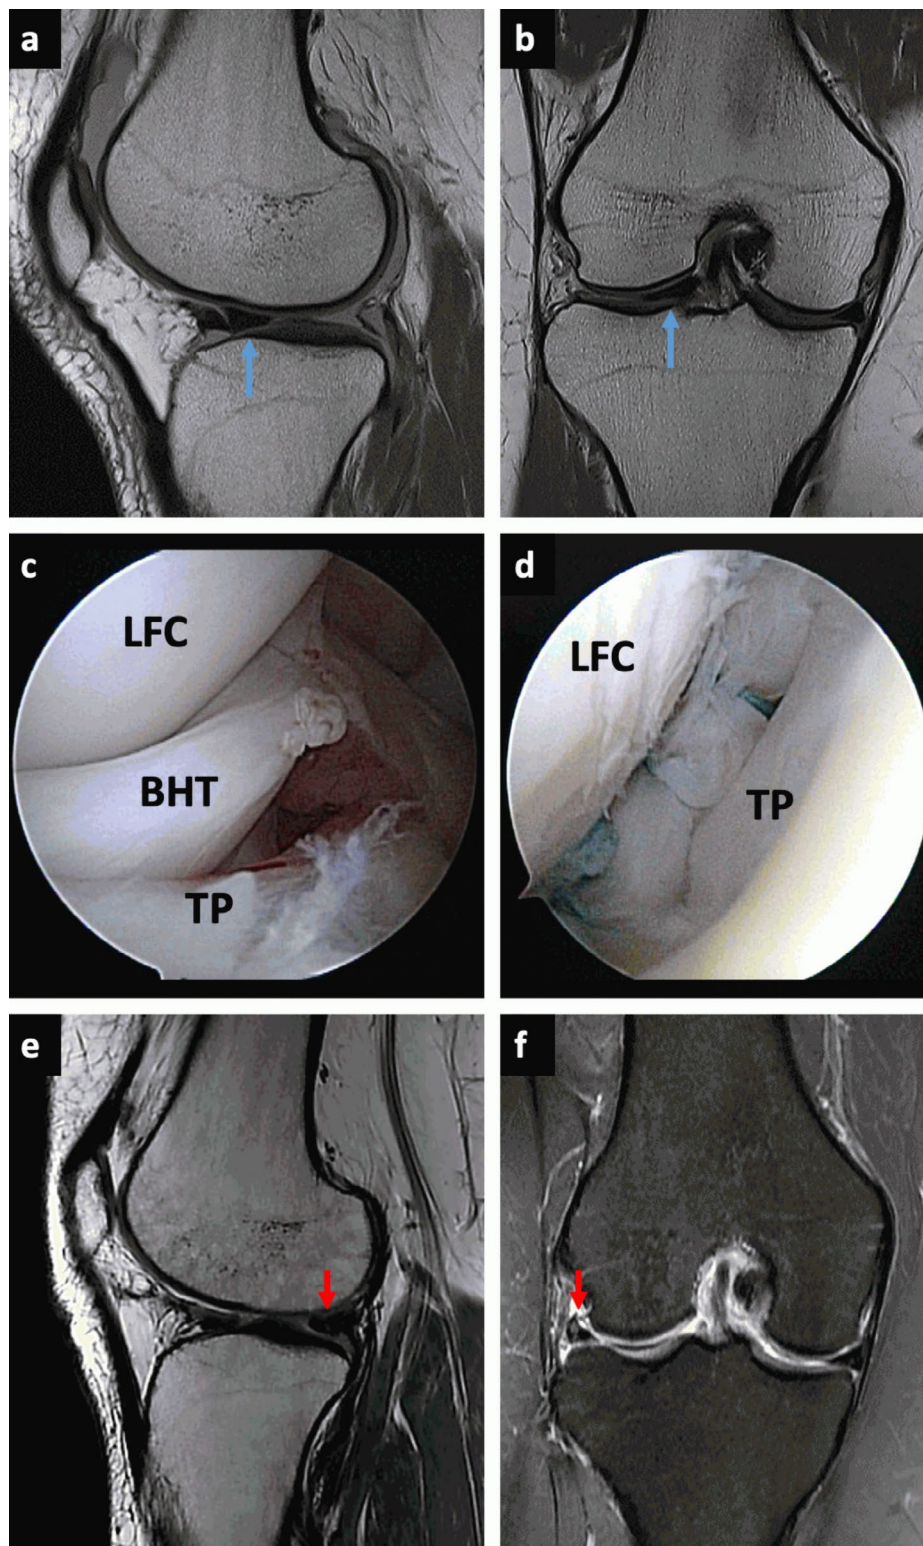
Complete healing of a lateral meniscus bucket-handle tear (a) Sagittal MRI view reveals double anterior meniscus (blue arrow). (b) Coronal MRI view shows a fragment in the intercondylar notch (blue arrow). (c) Preoperative arthroscopic image of the lateral meniscus bucket-handle tear. (d) Postoperative arthroscopic image of the all-inside wrapping repair suture technique. (e) Sagittal MRI view reveals reduction and healing of the posterior lateral meniscus (red arrow). (f) Coronal MRI view shows reduction and healing of the lateral meniscus (red arrow). LFC, lateral femoral condyle; BHT, bucket-handle tear; TP, tibia plateau
